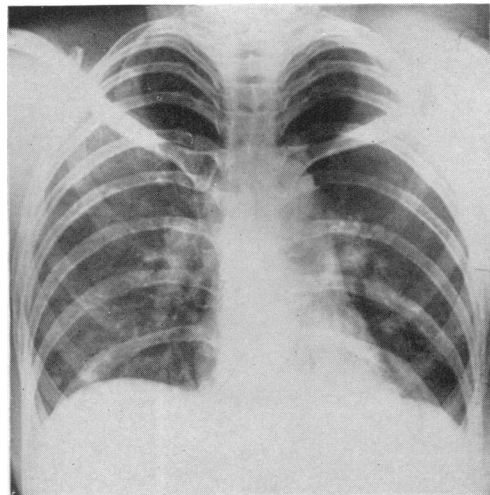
Case 4. Radiograph of chest, October, 1950.
